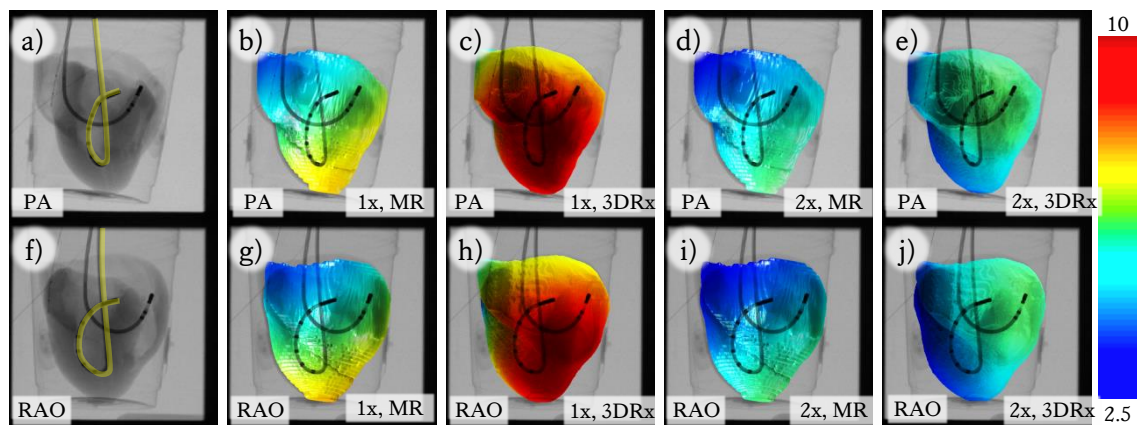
Visual representation of registration results using the b, c, g, h) biplane 1×BNHC strategy and d, e, i, j) biplane 2×BNHC strategy applied to the first looped catheter configuration. Colour mapping of the CT data surface rendering shows the spatial distribution of RPD. The data is overlaid onto X-ray in a, b, c, d, e) PA and f, g, h, i, j) RAO 45° views.
